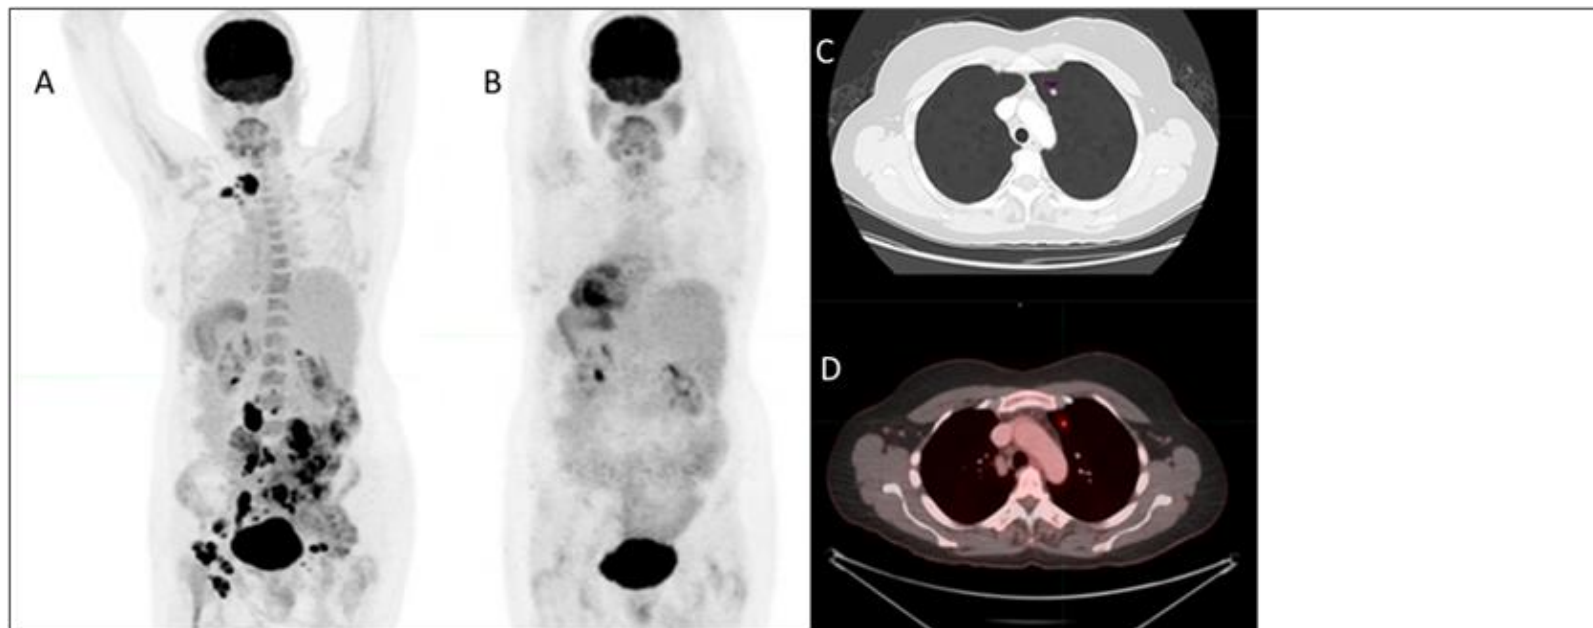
Images of 52 years old female with HL who subsequently developed lung cancer after treatment. A: Baseline PET scan showing multifocal hypermetabolic lymphadenopathy above and below the diaphragm. B: end of HL therapy PET scan showing complete response. C: A follow up axial CT chest after 1 year with IV contrast showing: subcentimeter pulmonary nodule in the left upper lobe which was later confirmed to be adenocarcinoma. D: An axial PET CT fusion showing an FDG-avid 0.8 cm left upper lobe pulmonary nodule with SUV of 5.5.
